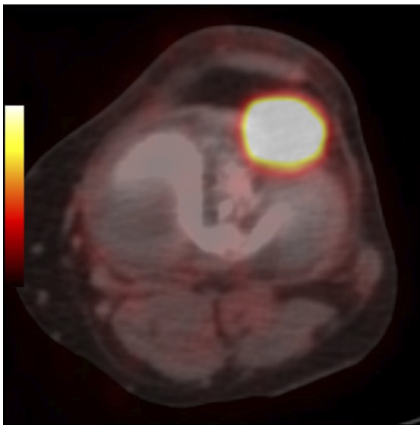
72-year-old man with giant-cell tumor of the tendon sheath. FDG PET/CT. Soft-tissue-windowed, transaxial fused PET/CT image shows intense FDG uptake within the mass. Maximum SUV was 25 g/ml.
